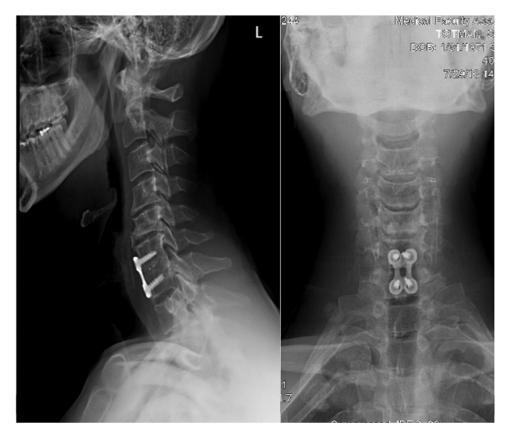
Preoperative x-ray images showing a C6/7 ACDF with some adjacent level degeneration at the C5/6 level and the C4/5 level. (Color version of figure is available online.)
